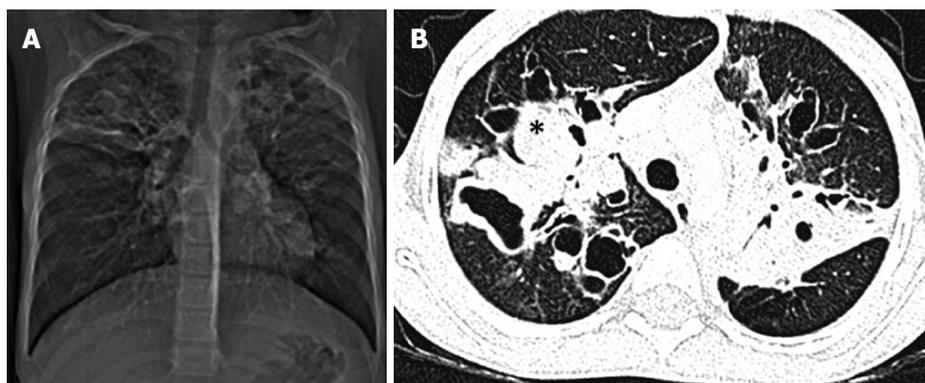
A 7-year-old boy with cystic fibrosis. Computed tomography (CT) scout image (A) and axial CT chest image (B) showing bilateral upper lobe bronchiectasis with bronchocele formation (asterisk) due to mucous plugging and sparing of lower zones.
